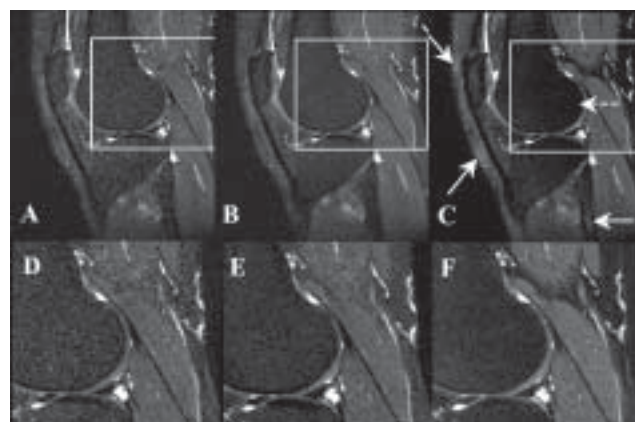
Calculated T2-weighted FSE water images for symmetric (a) and asymmetric (b) acquisitions, and FS-FSE (c) for comparison. Figs. 2d-f show magnified regions of Figs. 2a-c. Structured noise is seen in the marrow and soft tissue of the symmetric echo, and irregular interfaces between muscle and fat are best seen in (d). Failure of fat saturation is seen in the FS-FSE image (arrows), as well as shading within the posterior aspect of the lateral femoral condyle (dashed arrow).
